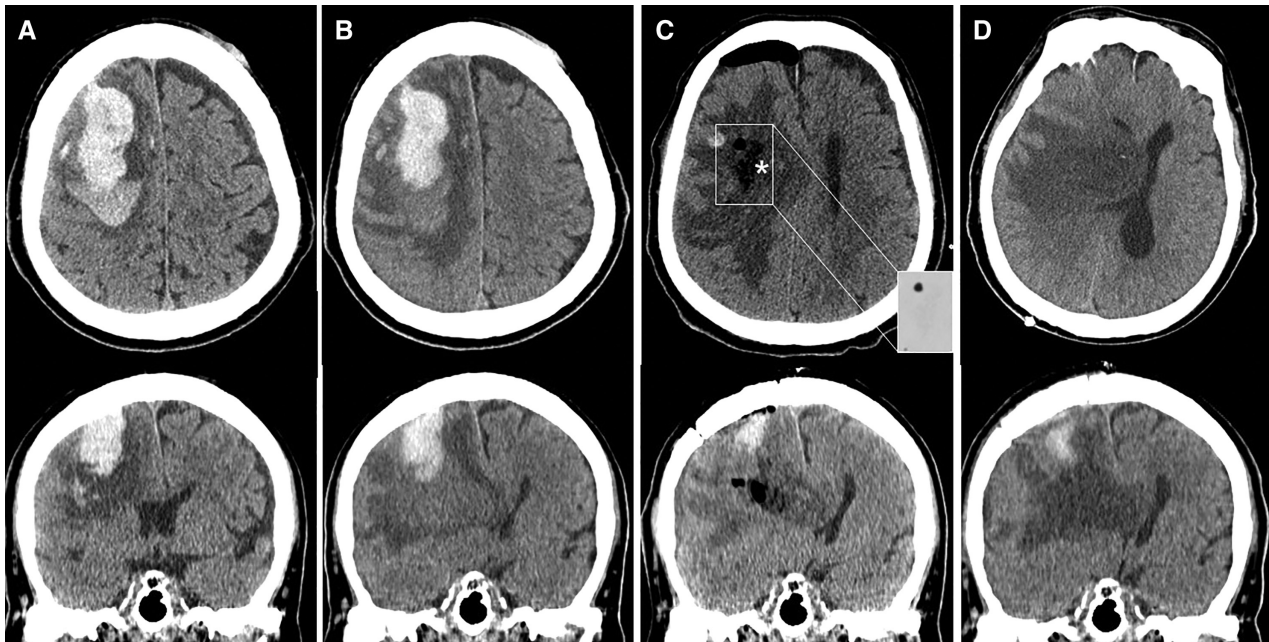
Brain CT on day 1 (A) and day 7 (B) after admission. (C) Brain CT on postoperative day 1 showing hematoma disappearance and pseudoair hypoattenuation (*) estimated with lung windows (window widths of 1500). (D) Brain CT on postoperative day 5 indicating subfalcine herniation caused by the cyst in the hematoma cavity. CT: computed tomography.
